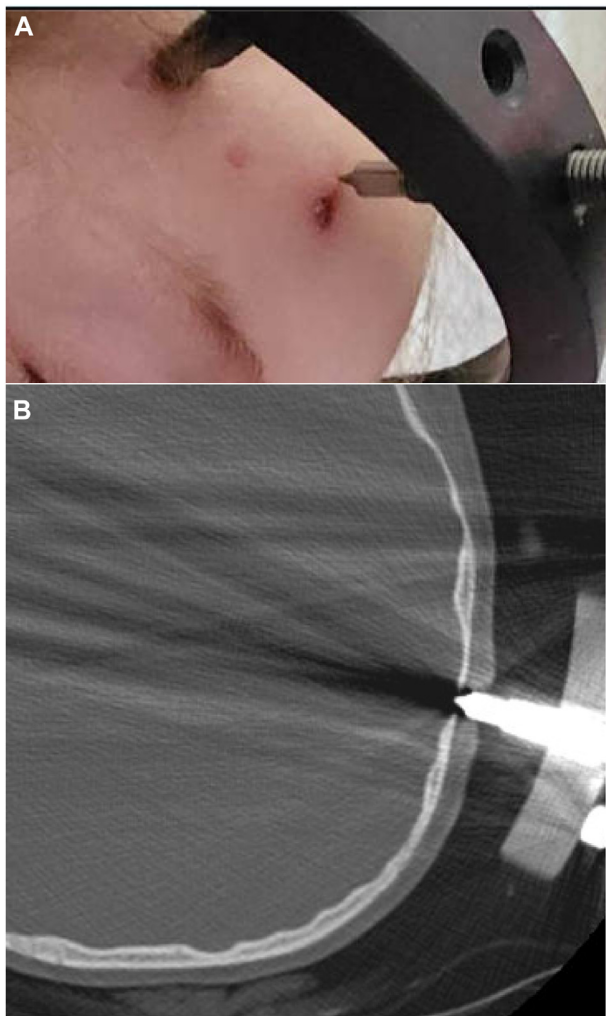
(A) Family sent a photo of a child in a halo vest who had fallen off a bed while jumping on it. A screw appeared to come loose and to have backed out. (B) A CT scan was obtained to evaluate the pins that demonstrated potential penetration of one screw opposite the backed-out screw. CT, computed tomography.
